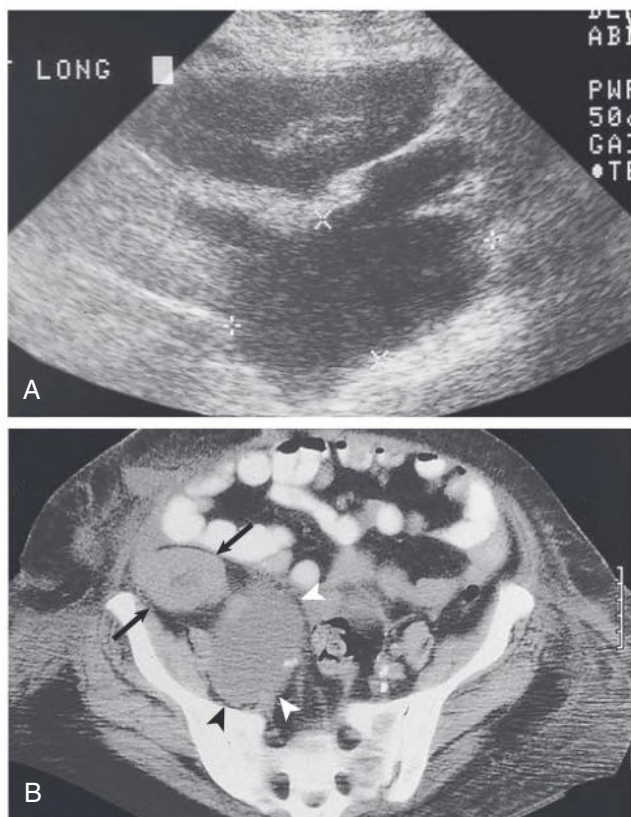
Posttransplantation Lymphocele. (A) Ultrasound appearance. A large, echolucent lymphocele can be seen inferior to the transplanted (marked by crosses). (B) Computed tomography appearance. A 5 × 5 cm lymphocele (arrowheads) is present under the transplanted kidney (arrows).
